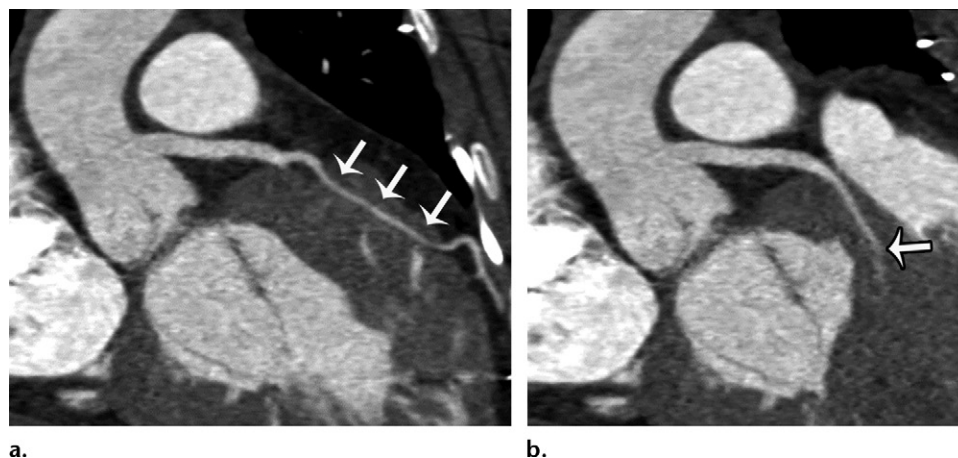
Myocardial bridging in a 16-year-old adolescent girl with hypertrophic cardiomyopathy. (a) Curved planar reformation from coronary CT angiography shows a long segment of deep myocardial bridging (arrows) of the LAD. (b) Image from the same study in a slightly different plane shows a septal perforating artery (arrow) that is distinct from the bridging and terminates in the myocardium, a normal finding.
